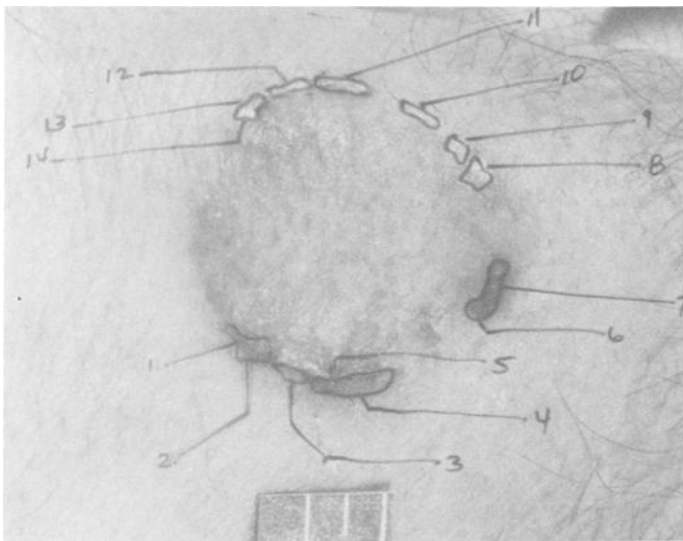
Radiographic overlay of decedent's dentition and bite mark.
